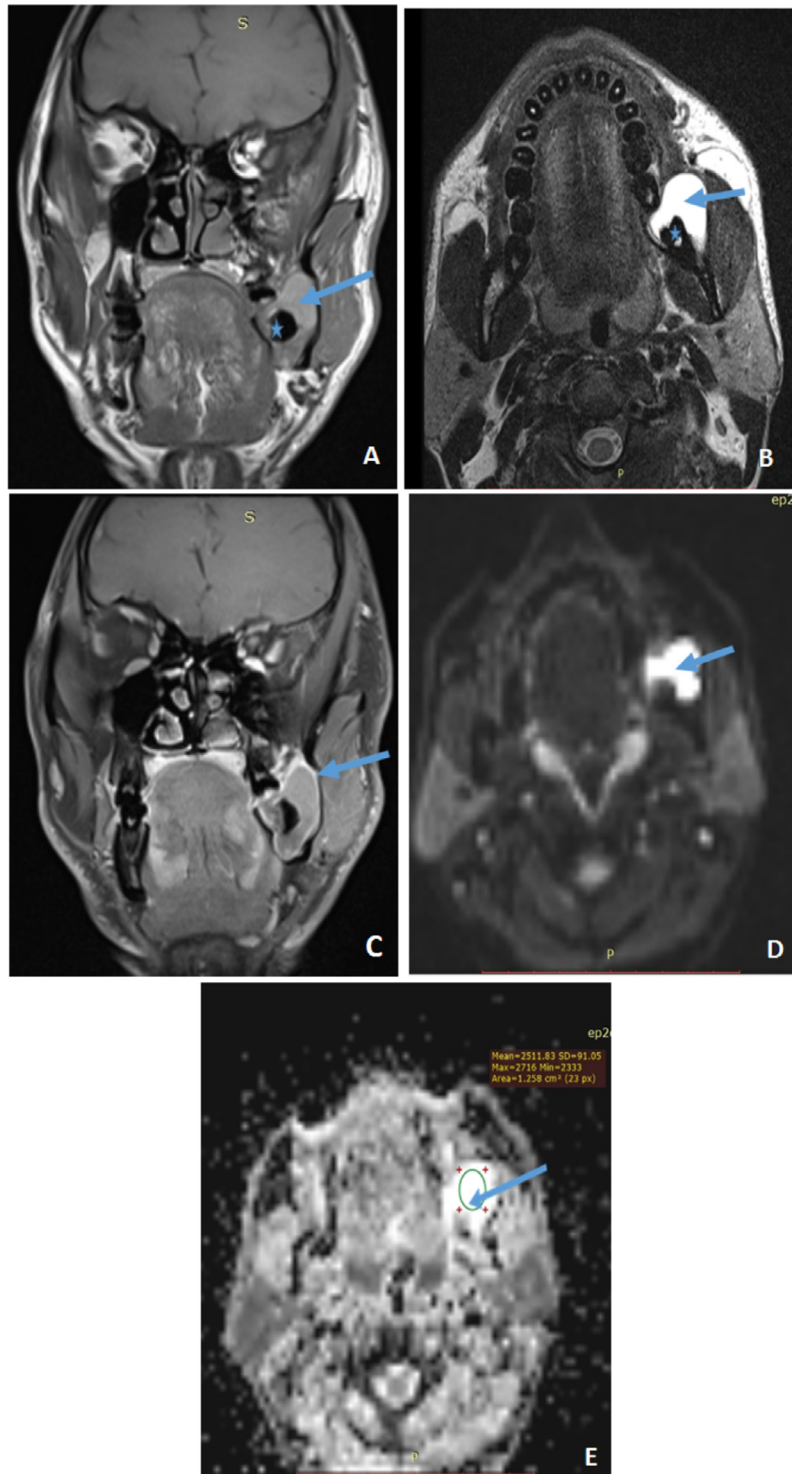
A–E, A 28-year-old male patient with dentigerous cyst (DC). Coronal T1-weighted magnetic resonance imaging (MRI) scan (A) shows a well-defined lesion (*blue arrow*), with an associated impacted tooth (*asterisk*) appearing mildly hyperintense relative to muscle. Axial T2-weighted MRI scan (B) shows markedly hyperintense signal intensity of the lesion (*blue arrow*) surrounding the impacted tooth (*asterisk*). Coronal postcontrast T1-weighted MRI scan (C) shows a peripheral thin rim (~ 2 mm) of enhancement. Axial diffusion-weighted imaging (DWI) scan at $b=800 \text{ mm}^2/\text{sec}$ (D) and corresponding apparent diffusion coefficient (ADC) map (E), both reveal a hyperintense signal (*blue arrows in D and E, green circle in E*), suggestive of facilitated diffusion with a mean ADC value of $2.511 \times 10^{-3} \text{ mm}^2/\text{s}$.
